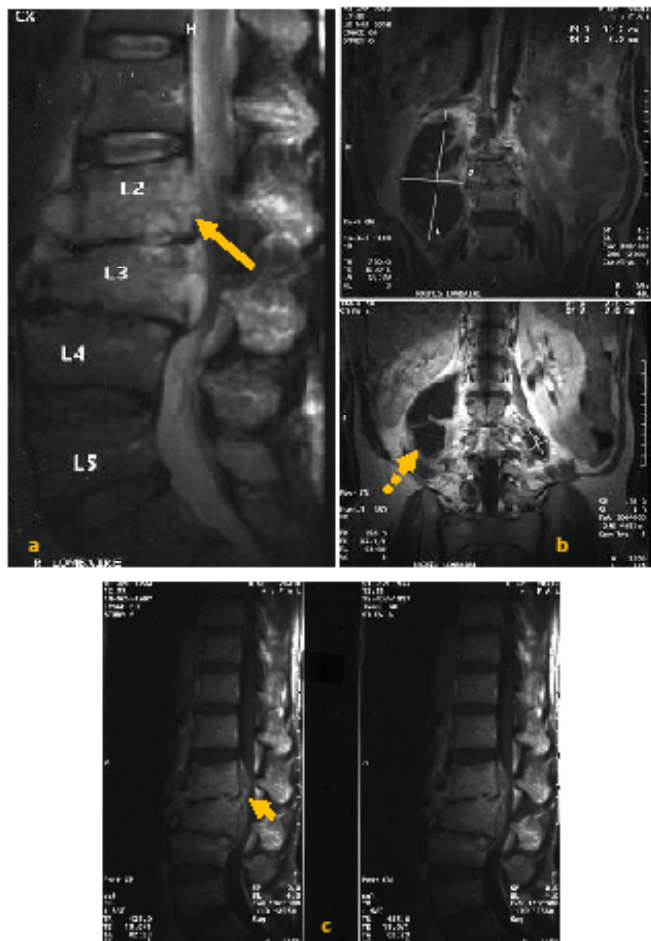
MRI of the lumbar spine in sagittal T2 STIR (a) and T1 with fat saturation and gadolinium contrast-enhanced coronal (b) and sagittal (c) sections demonstrating diffuse T2 hyperintensity involving the disc and vertebral bodies (arrow), heterogeneously enhancing after gadolinium injection, along with an epiduritis (arrowhead) compressing the cauda equina nerve roots and a bilateral psoas abscess (dotted arrow) more clearly visible in the coronal sections, measuring 12.5x6 cm on the right and 2x3.7 cm on the left.
